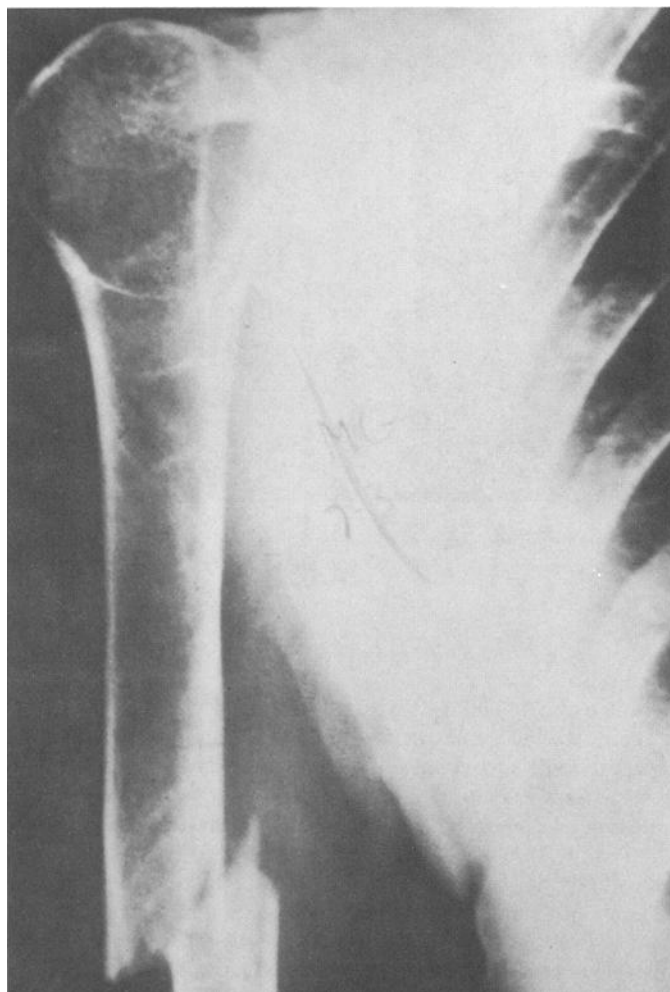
Antemortem radiograph.
